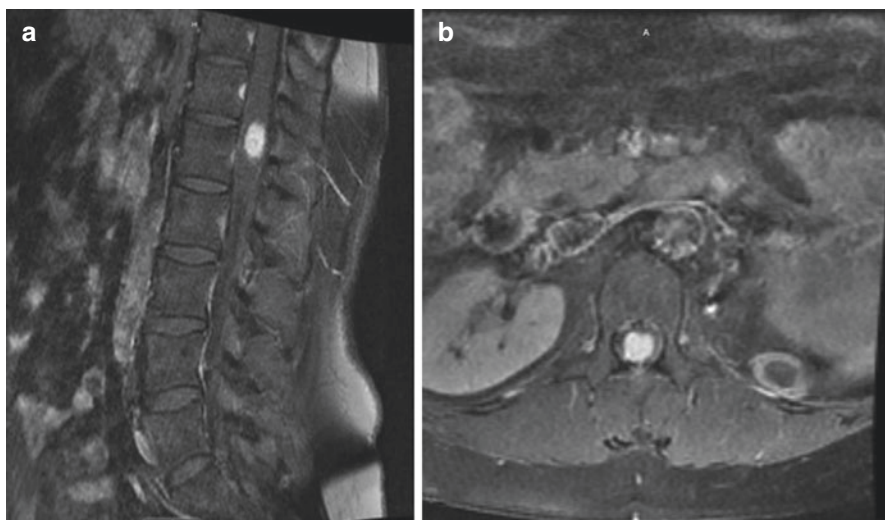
Renal cell carcinoma metastasis. An MRI of the lumbar spine that is significant for an enhancing conus medullaris lesion seen on T1 post-contrast sagittal (a) and axial (b) cuts
